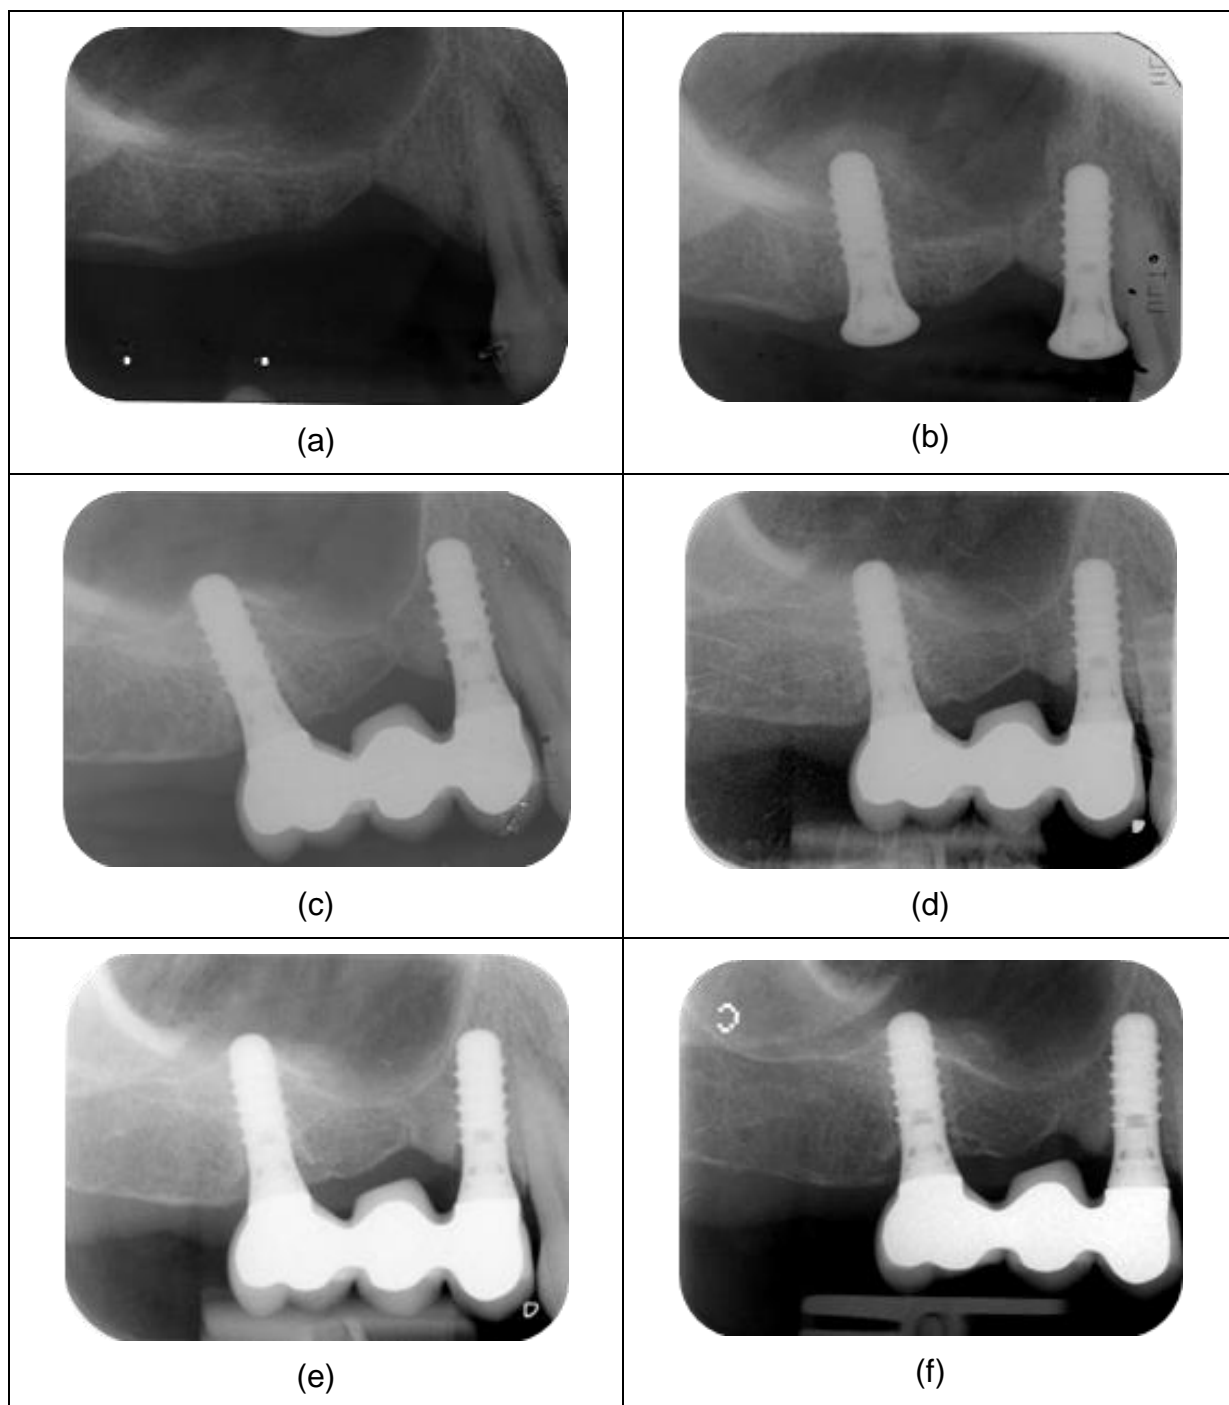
Radiographic evolution of sinus demarcation after the osteotome sinus floor elevation procedure without grafting material. Radiographs taken: (a) before implant placement; (b) immediately after implant placement; (c) at 1 year; (d) at 3 years; (e) at 5 years; and (f) at 10 years.
